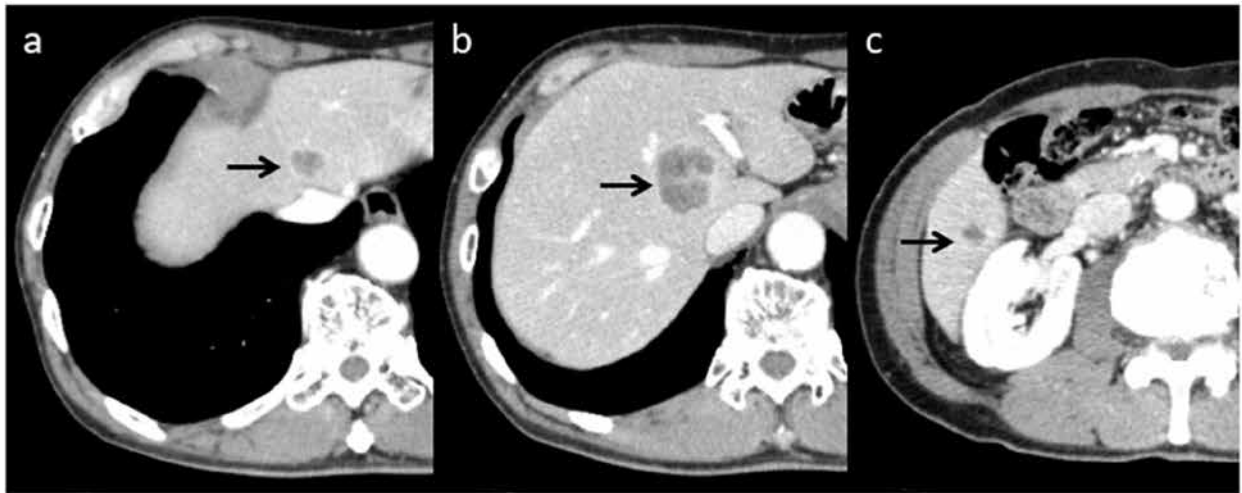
A contrast-enhanced abdominal computed tomography scan showing multiple low-density areas (arrows) measuring 30 mm in diameter at their widest points in the S2 (a), S4 (b), and S6 (c) liver segments
